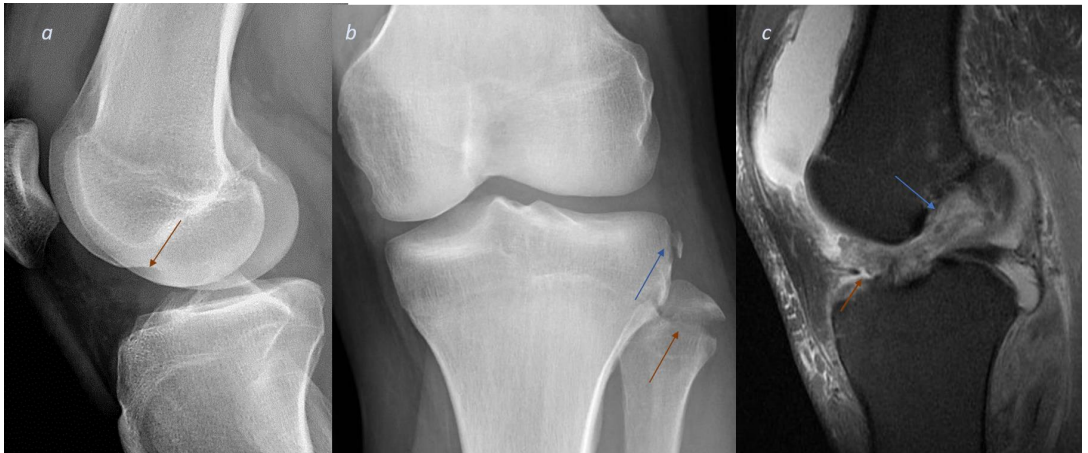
Lateral radiograph showing the distinct lateral femoral impression associated with valgus trauma and ACL rupture. 4b. Coronal radiograph showing a Segond fracture (blue arrow) and fibula head avulsion (red arrow), which have 95% and 90% association, respectively, with ACL rupture. 4c. The ACL is thickened (blue arrow) with a ruptured part of the ligament lying anteriorly (red arrow).
